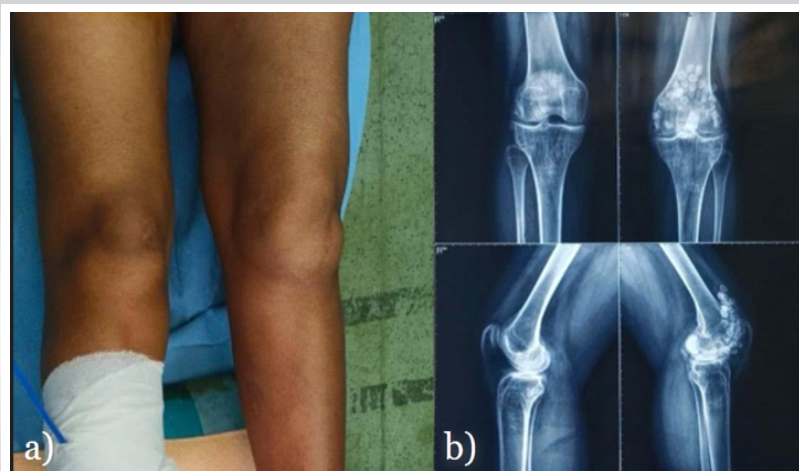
(a) Pre-operative clinical photograph showing swollen left knee due to multiple intra-articular loose bodies in the suprapatellar pouch and joint cavity, (b) Pre-operative anteroposterior and lateral radiographs of the left knee demonstrating multiple calcified intra-articular loose bodies with secondary arthritic changes.
